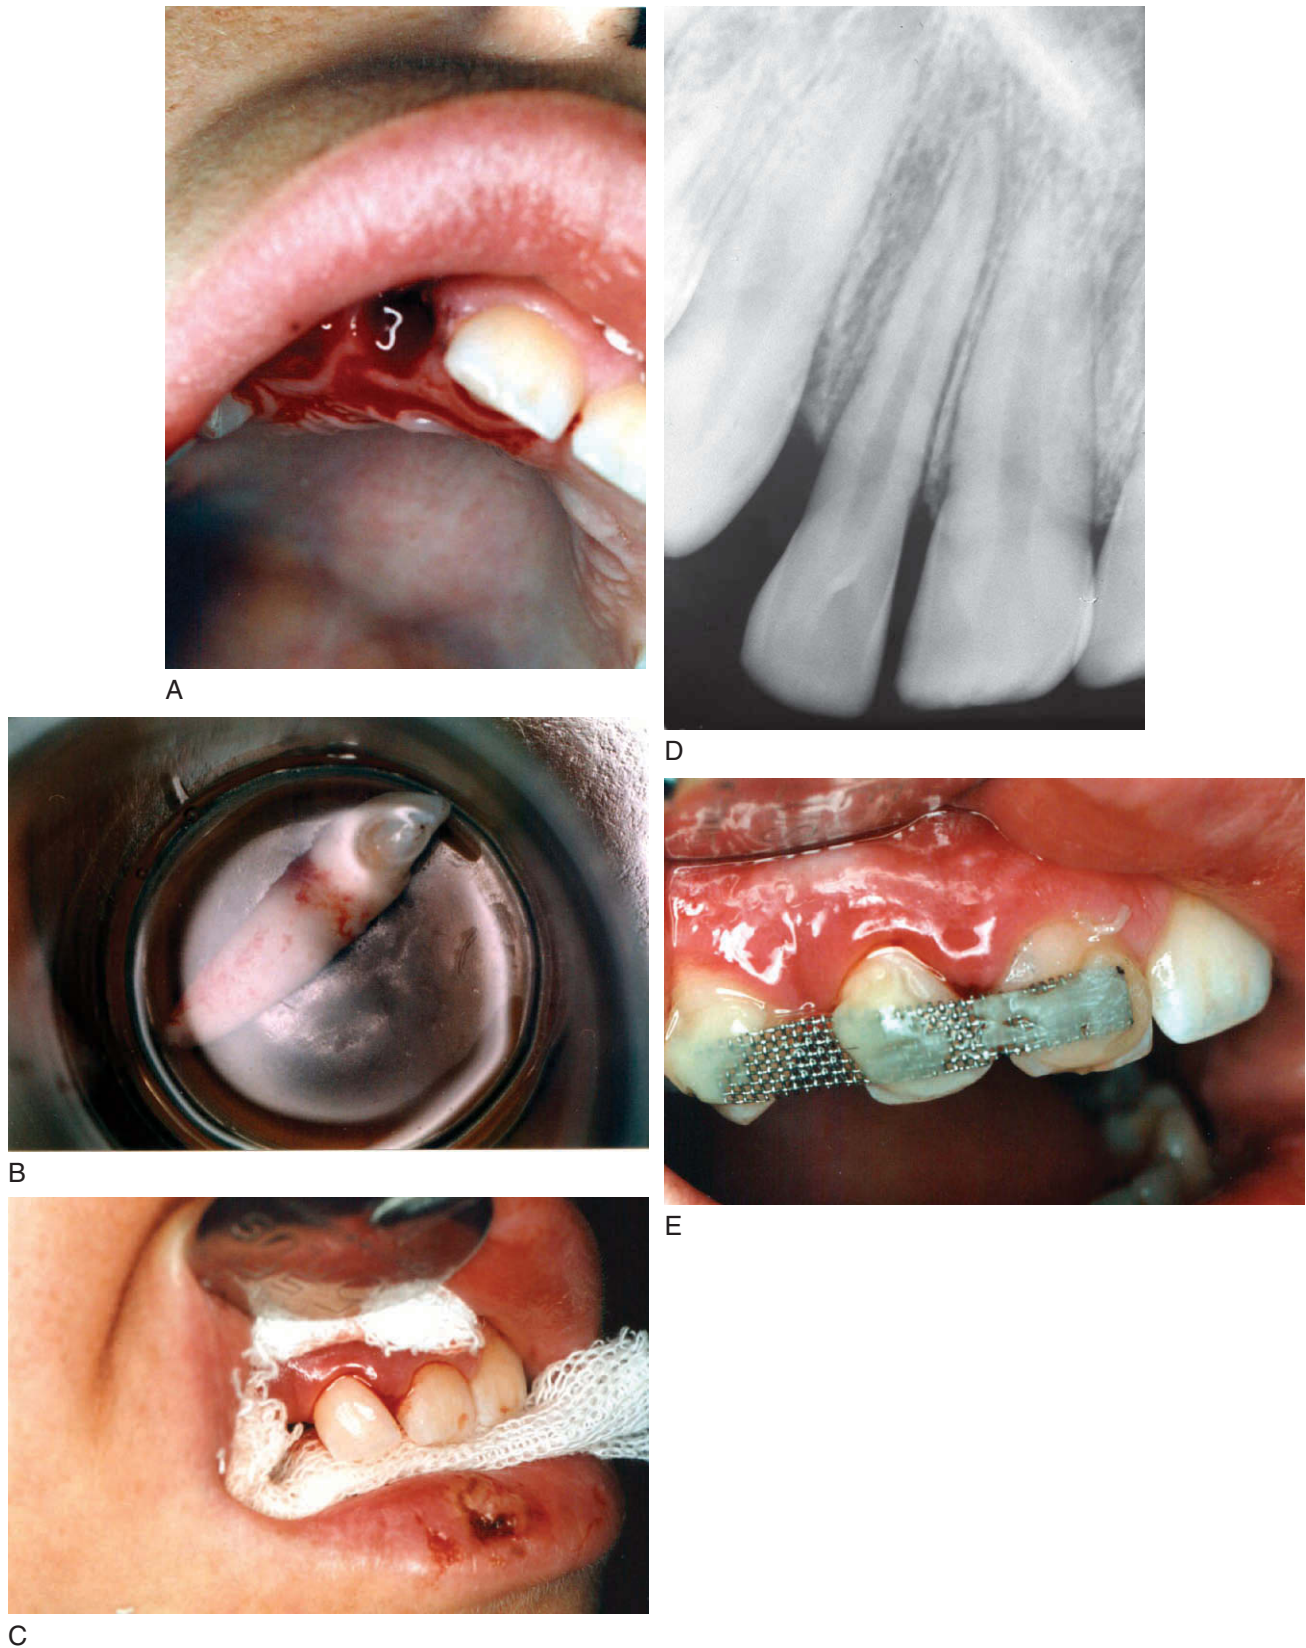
A, Observation 2 hours after avulsion, maxillary right lateral incisor. B, Storage of tooth in HBSS before replantation. C, Tooth replanted with patient biting on gauze while splint is being fabricated. D, Radiographic verification of proper repositioning of tooth. E, Tooth splinted.
